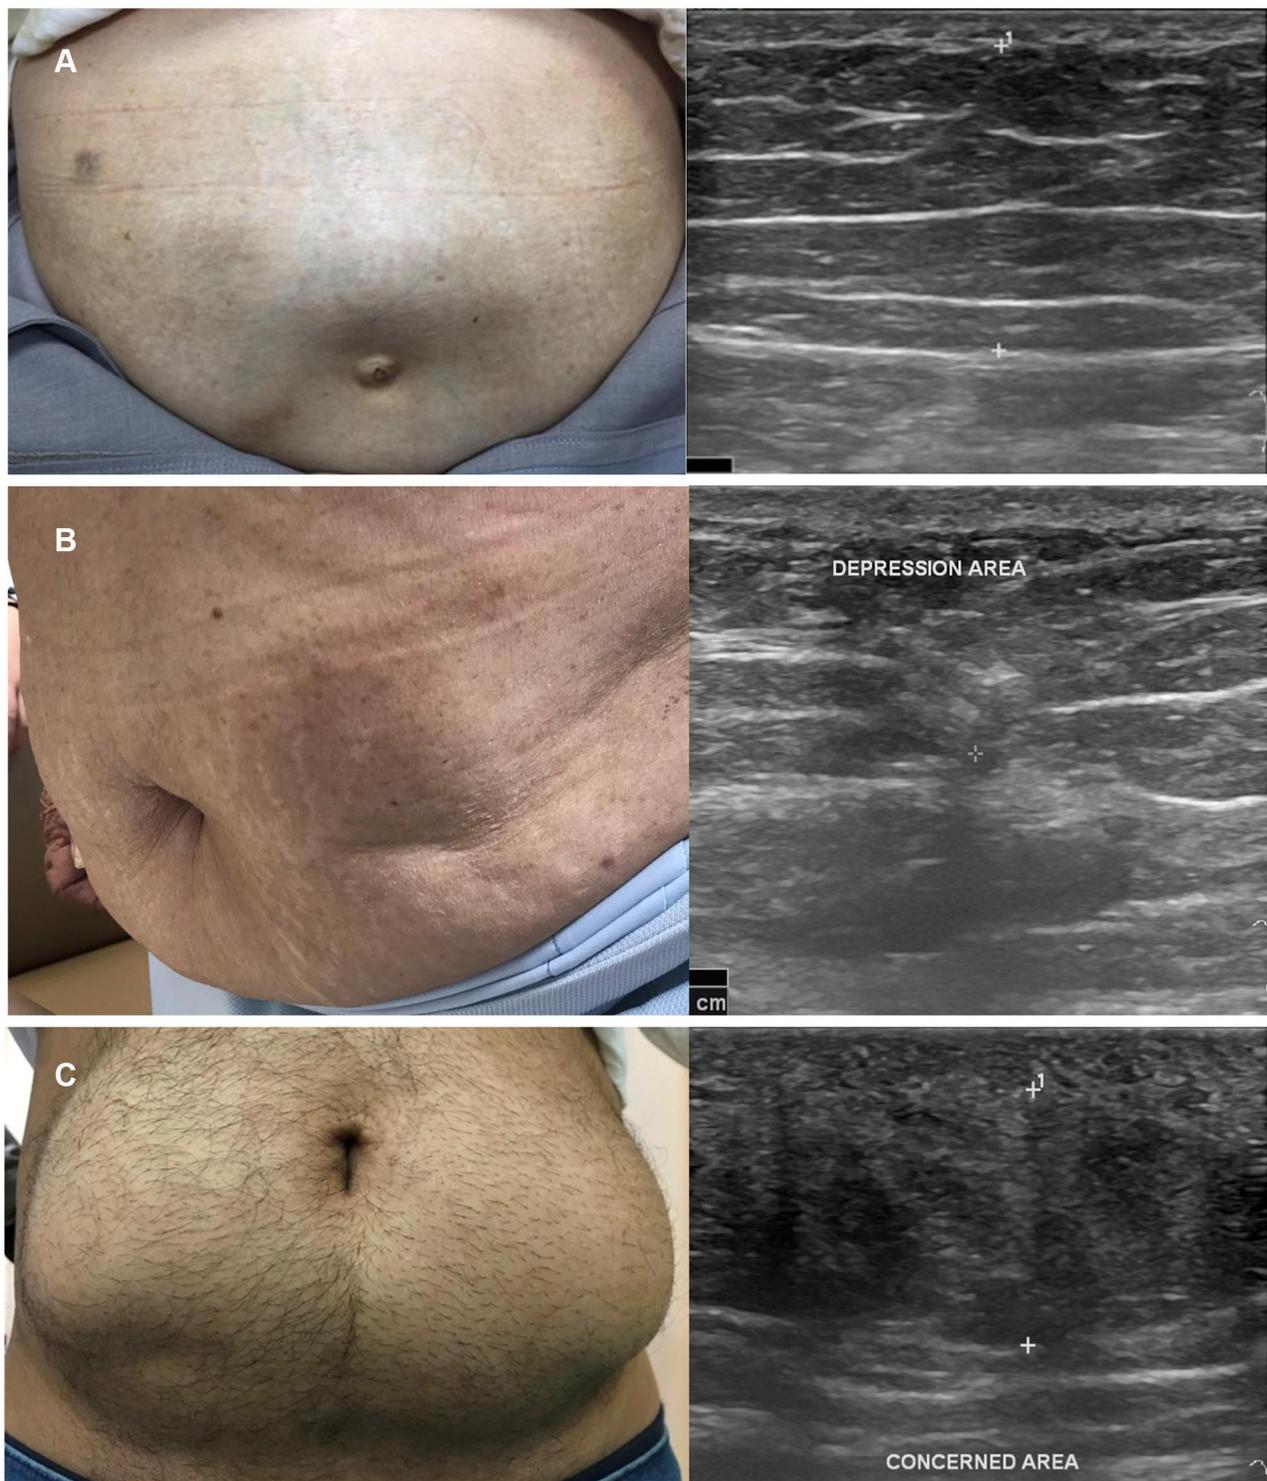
(A) A typical insulin-induced lipohypertrophy in T2DM patient with ultrasound characteristics of thickening heterogeneous echogenicity of subcutaneous fat. (B) Insulin-induced lipoatrophy in a patient with long-standing T2DM with ultrasonographic findings of lipoatrophy revealed a focal area of decreased thickness and increased heterogeneous echogenicity of subcutaneous fat texture. (C) AT1DM patient with suspected insulin-derived localized amyloidosis based on palpable subcutaneous mass at subumbilical region and homogeneous hypoechoic fat interspersed from ultrasound.
